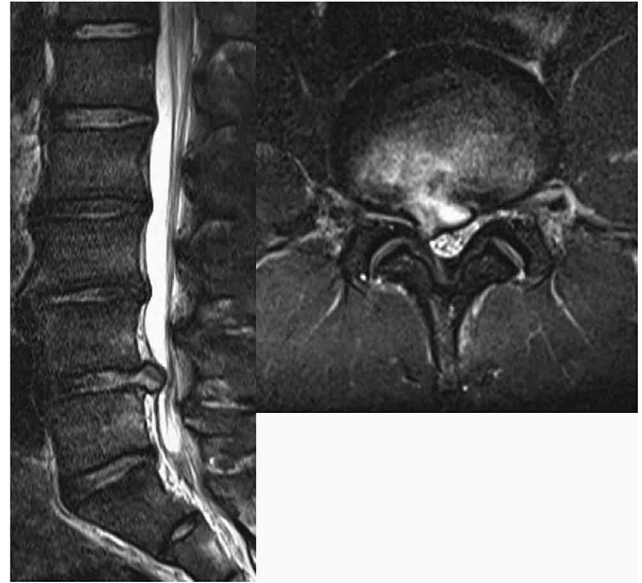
Recurrence of the lumbar disc herniation on the right side of L4/5. MRI revealed right paracentral disc protrusion at L4/5 level. PED had been performed 2 years ago for disc herniation on the same side and at the same level.
